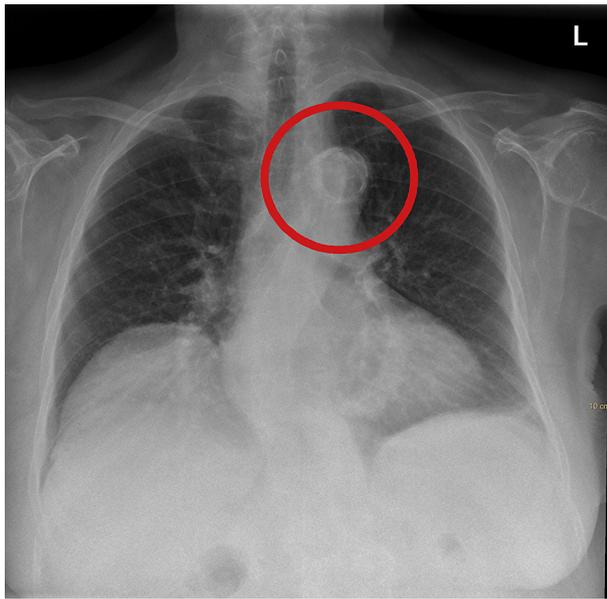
Chest radiograph of an 81-year-old woman in whom the surgical approach was altered due to extensive aortic calcifications (red circle).
